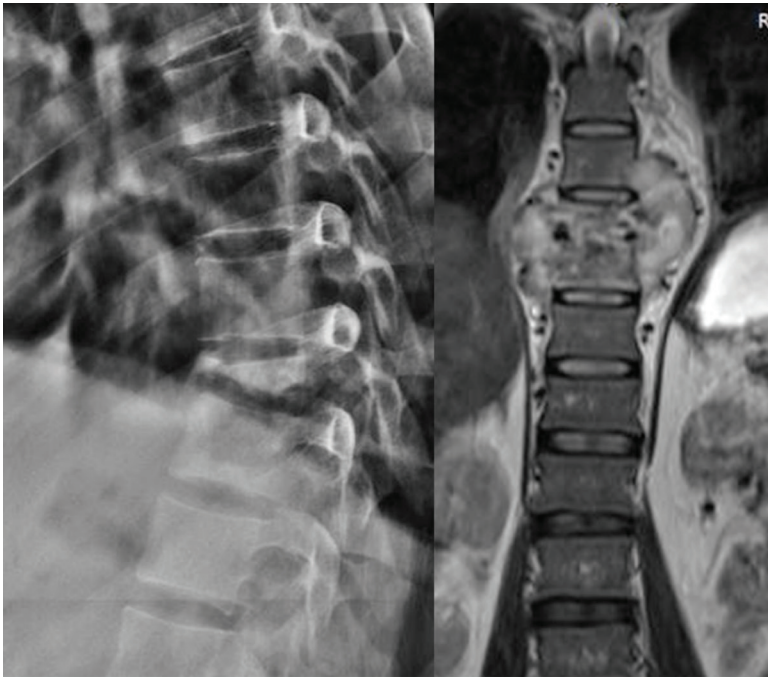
Patient with acquired immunodeficiency syndrome under treatment for pulmonary TB that evolved with decreased muscle strength in the lower limbs. The images show the destruction of the vertebral body and a paraspinal abscess. The left lateral radiography shows collapse of the intervertebral disc and vertebral bodies at T10-T12 that are sclerotic. The right T2 image by Magnetic Resonance Imaging (MRI) presents a paravertebral abscess and destruction of the thoracic vertebra and the intervertebral discs, associated with an exuberant paravertebral soft tissue component and dorsal kyphosis.
